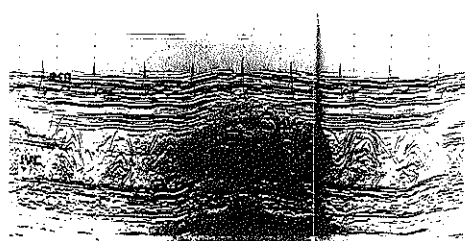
M-mode contrast inferior vena cava echocardiogram showing a v-wave synchronous pattern typical for tricuspid regurgitation. Note the increased contrast effect due to inspiration in the middle of the figure. All of the contrast in the hepatic vein (HV) and most of the contrast in the IVC has an upward slope during the early part of systole, indicating retrograde flow coming toward a superiorly directed transducer, and a negative slope as the contrast returns towards the heart during the latter part of the v-wave, in early diastole.
